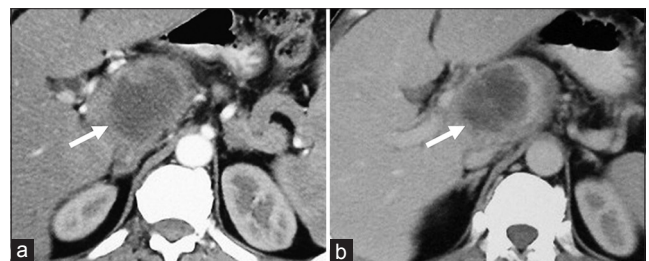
62-year-old man with hepatic tubercular abscess. Axial CECT images of the liver in (a) arterial and (b) portal venous phases reveal a solitary well-defined hypodense lesion (arrow) with peripheral rim of enhancement in the caudate lobe. Ultrasound guided fine needle aspiration biopsy (not shown) of the lesion revealed caseous necrosis with tubercle bacillus and epithelioid giant cells.
